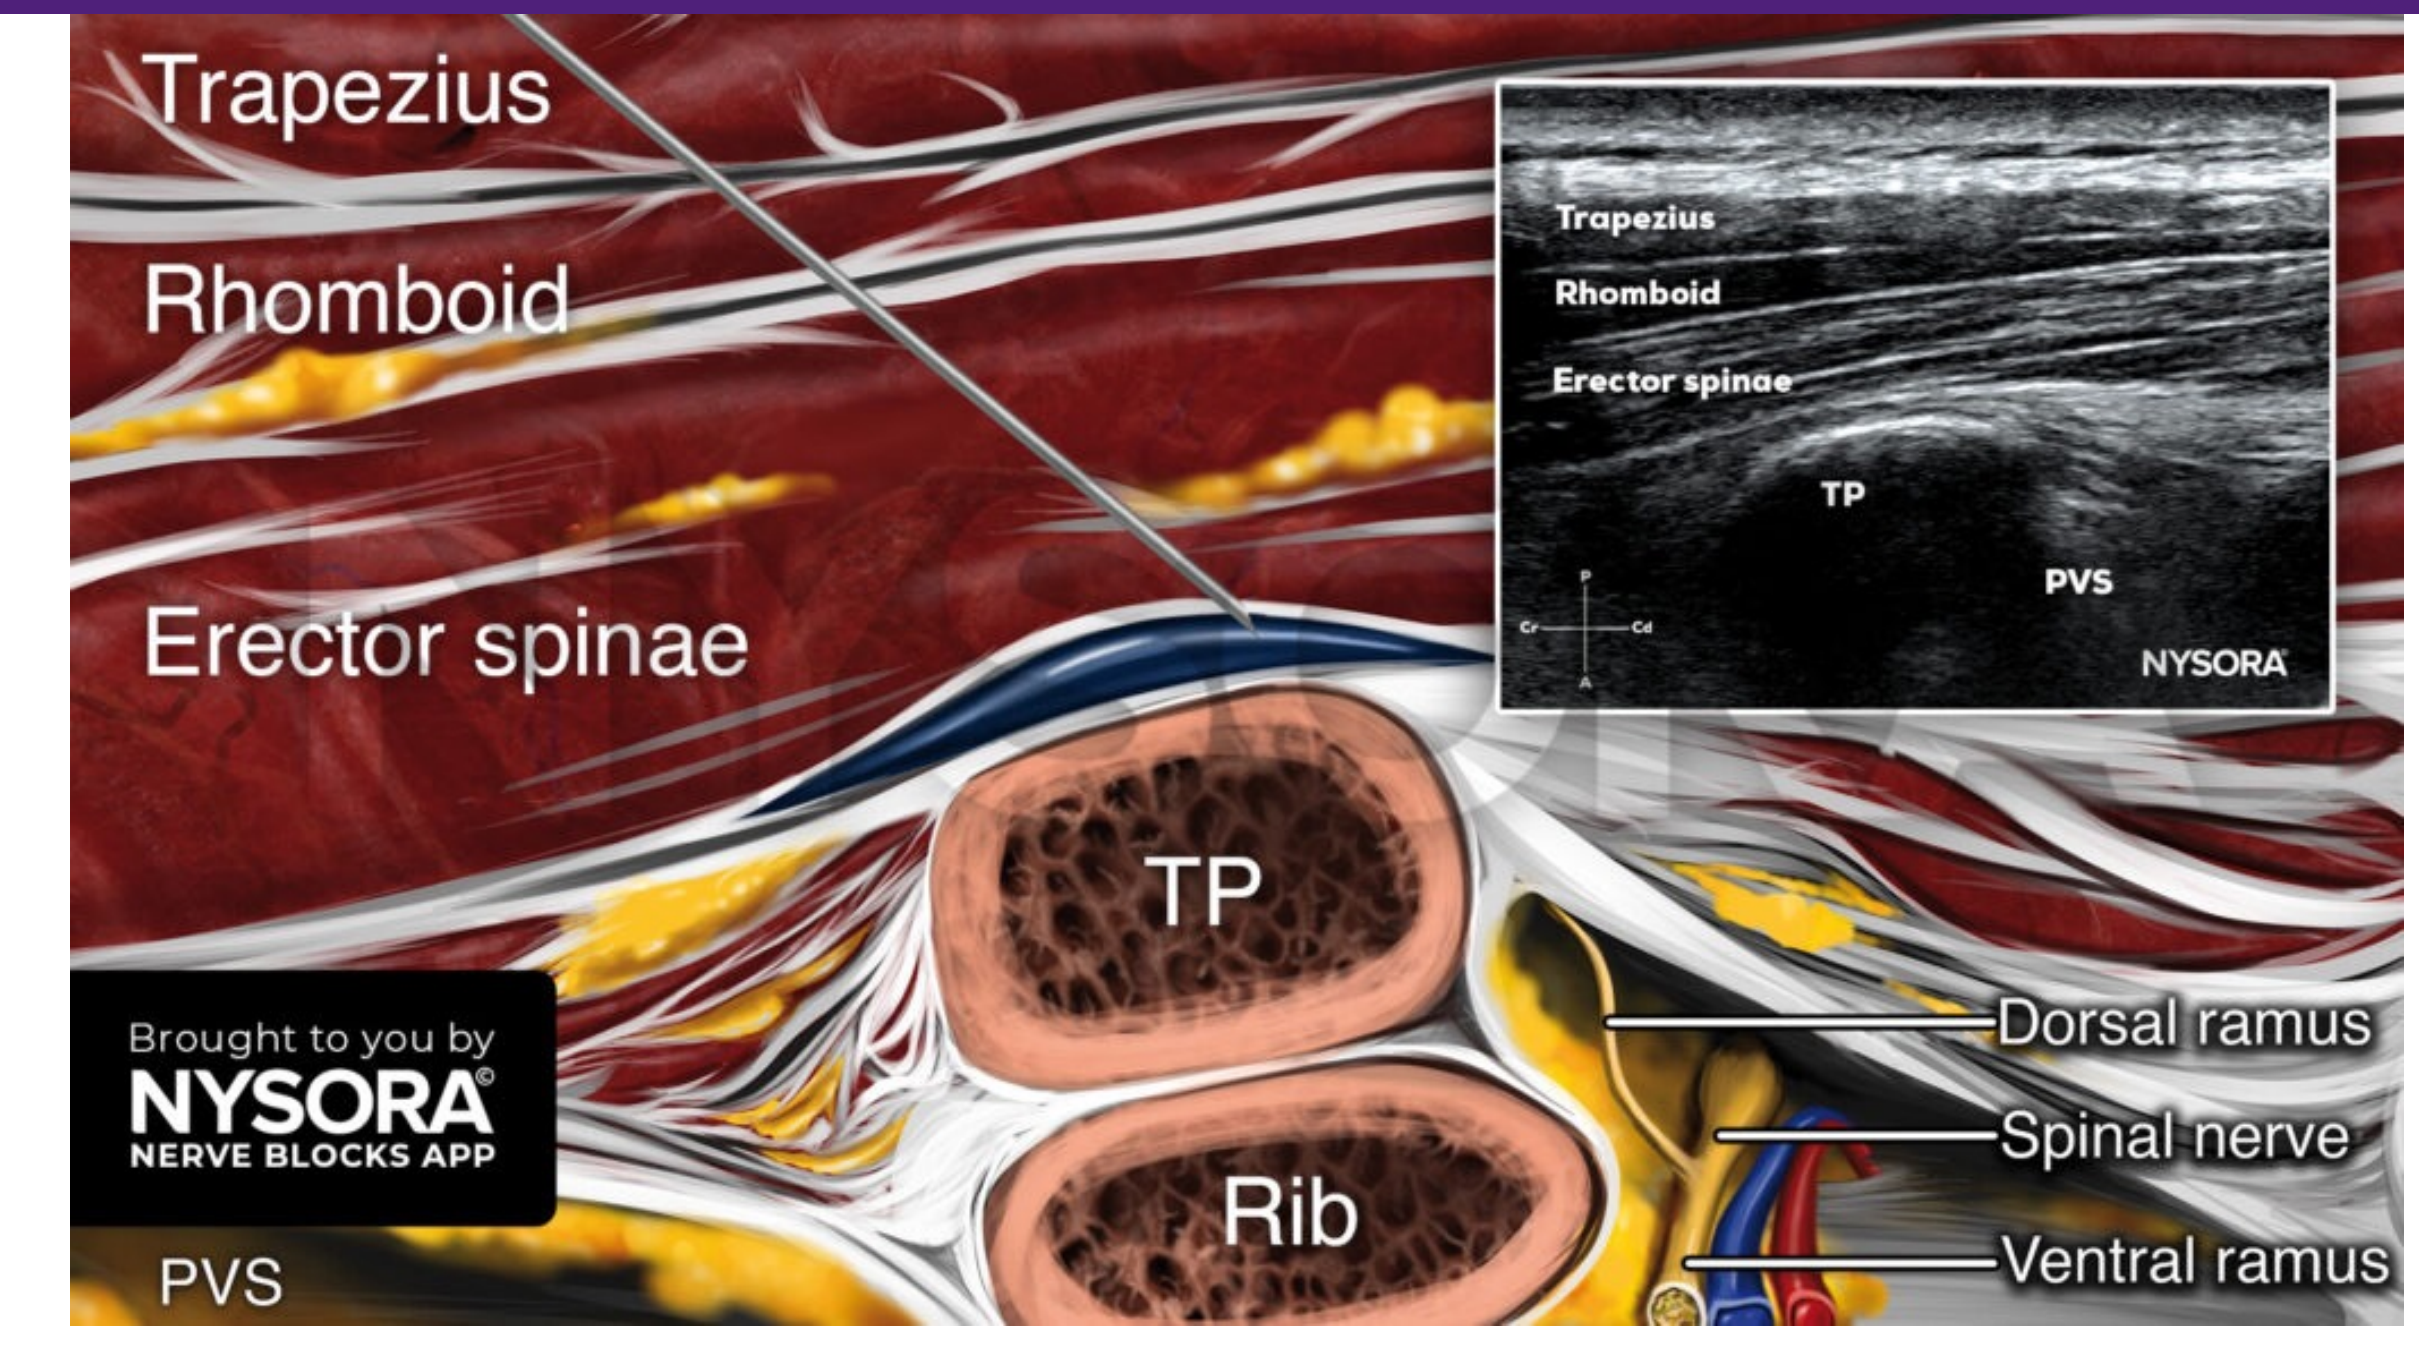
Anatomical landmarks and target for ultrasound-guided ESPB⁷
